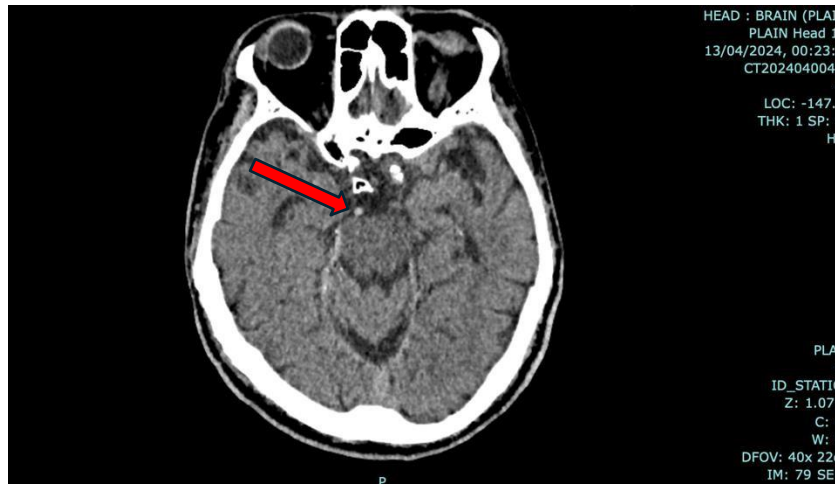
Non-contrast CT shows hyperdense basilar sign
